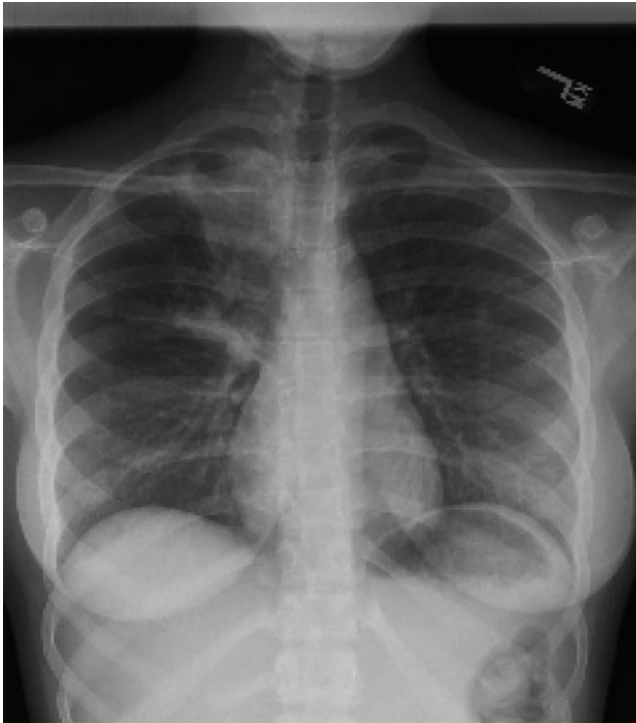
Chest X-ray showing right upper lobe consolidation with cavitation.
